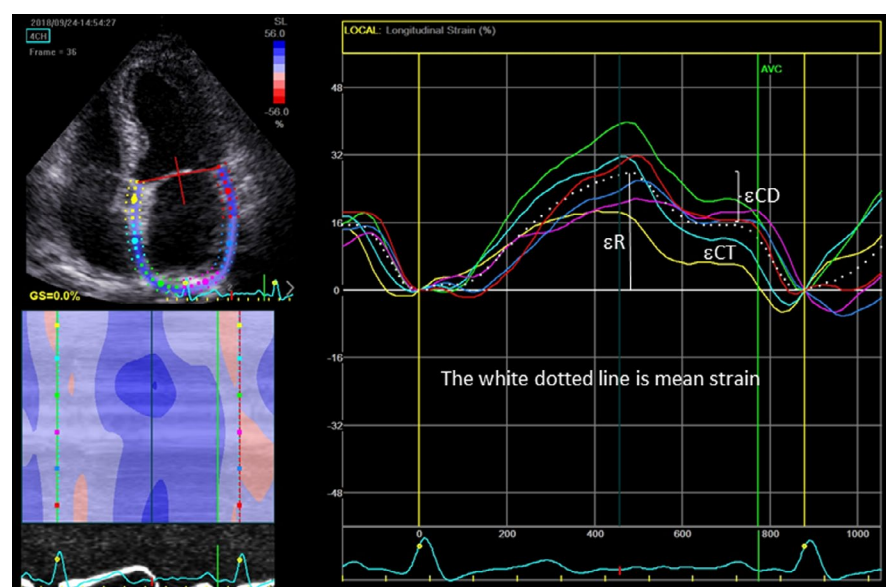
Left atrial strain analysis by speckle-tracking echocardiography. ϵ_{CD} = conduit strain; ϵ_{CT} = contractile strain; ϵ_R = reservoir strain
